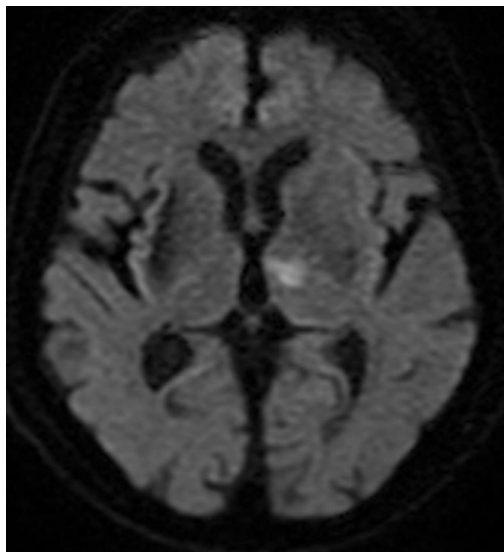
Head magnetic resonance imaging at the admission time. Axial plane including thalamus is taken with diffusion-weighted image. Ischemic lesion at the anterior nuclei of left thalamus is visualized to high intensity signal spot.
